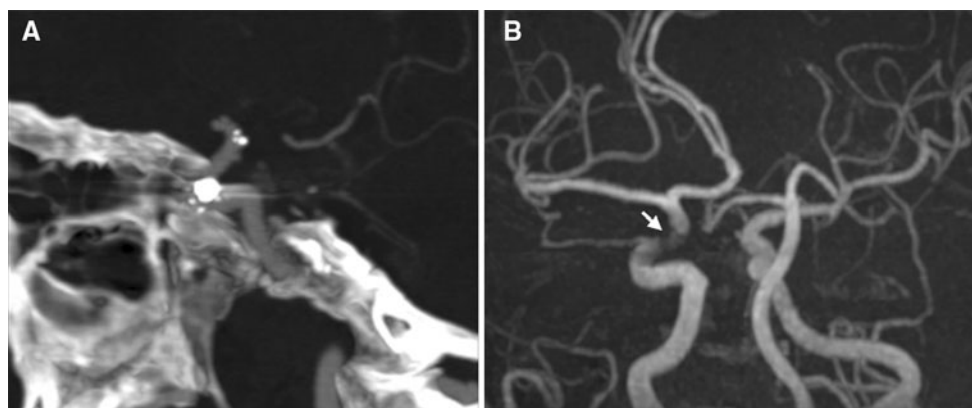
a A sagittal maximum-intensity projection image of computed tomographic angiography performed on admission shows the status of the previous stent-assisted coil embolization of an aneurysm on the right distal internal carotid artery. b Three-dimensional time-of-flight
